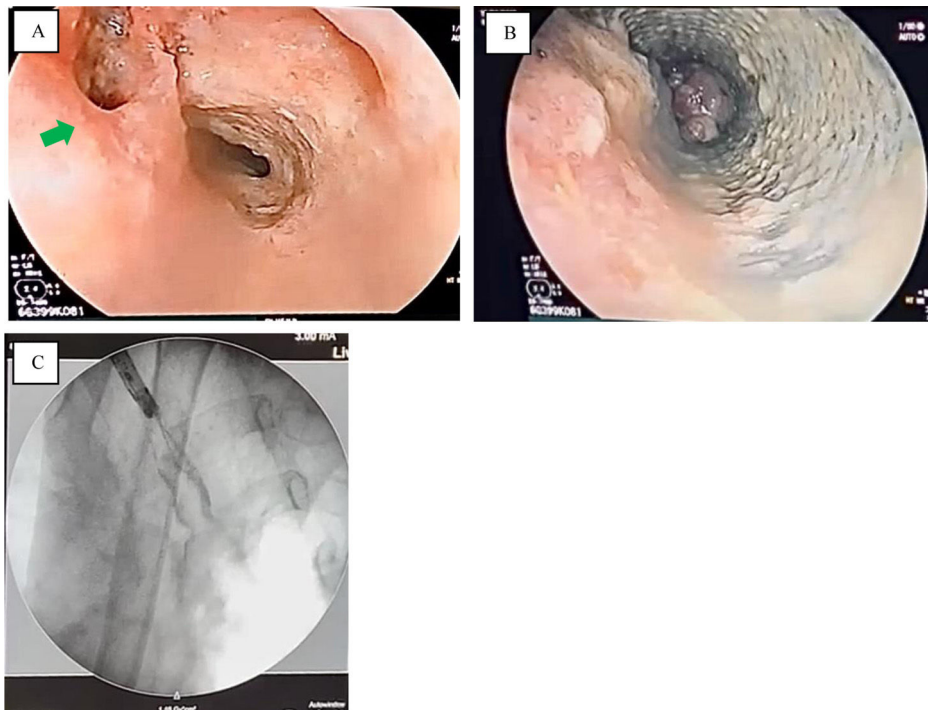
A) Esophagogastroduodenoscopy, showing the double lumen esophagus, with the ostium of the duplication to the left of the image (green arrow) and the "true" lumen in the center. B) Endoscopic image following the placement of the esophageal endostent, isolating the ostium's lumen and enabling the passage of food exclusively through the "true" lumen. C) Radiographic confirmation of the placement of the esophageal stent.
